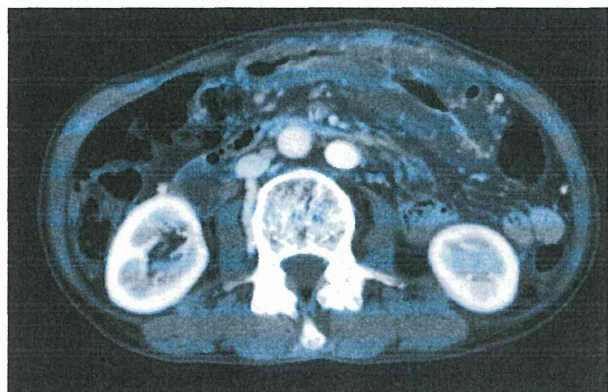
Multi-detector computed tomography image. Air is trapped in diffusely thickened gastric wall.
